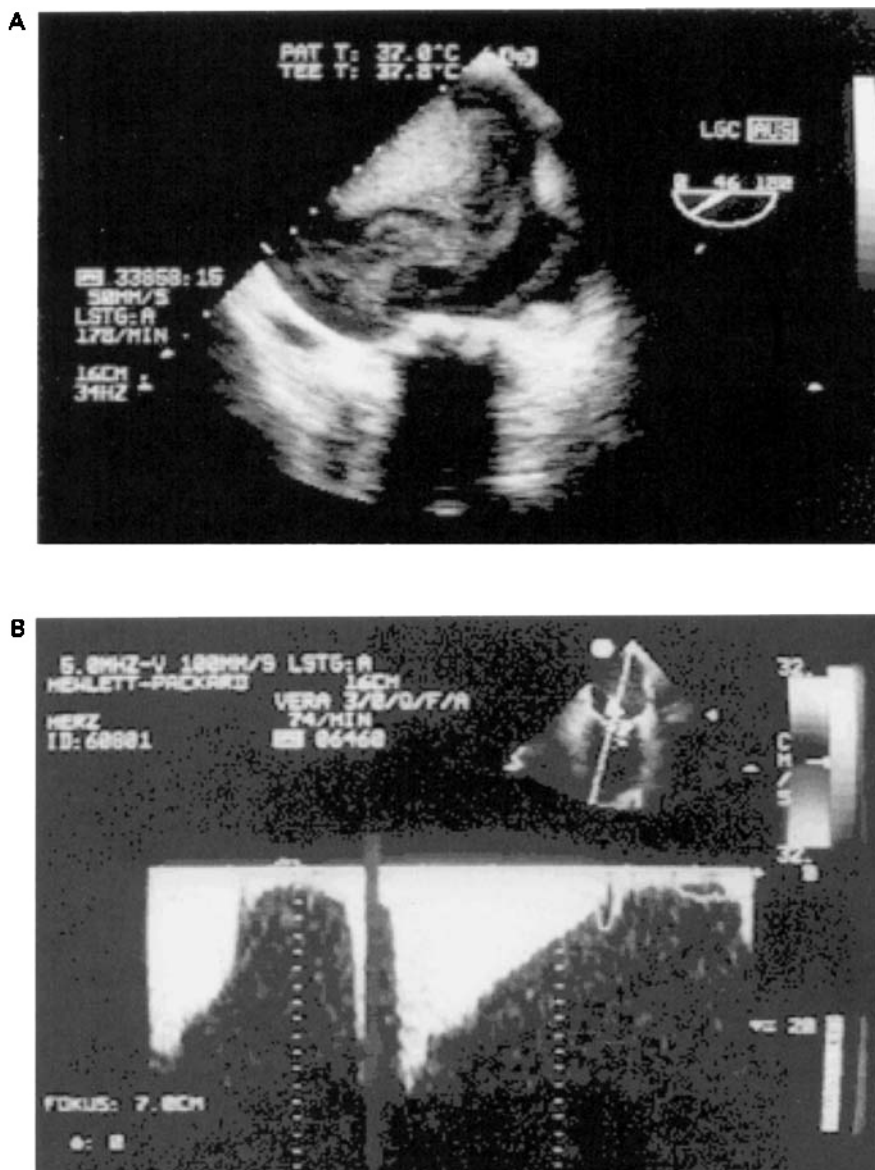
Transoesophageal echocardiography in severe mitral stenosis. (A) The enlarged left atrium is filled with massive spontaneous echo contrast. The stenotic and immobile mitral valve is severely thickened and calcified. (B) Continuous wave Doppler showing a peak instantaneous pressure gradient of 27 mmHg. The pressure half-time is prolonged, resulting in a calculated mitral valve area of 1.0 cm².
